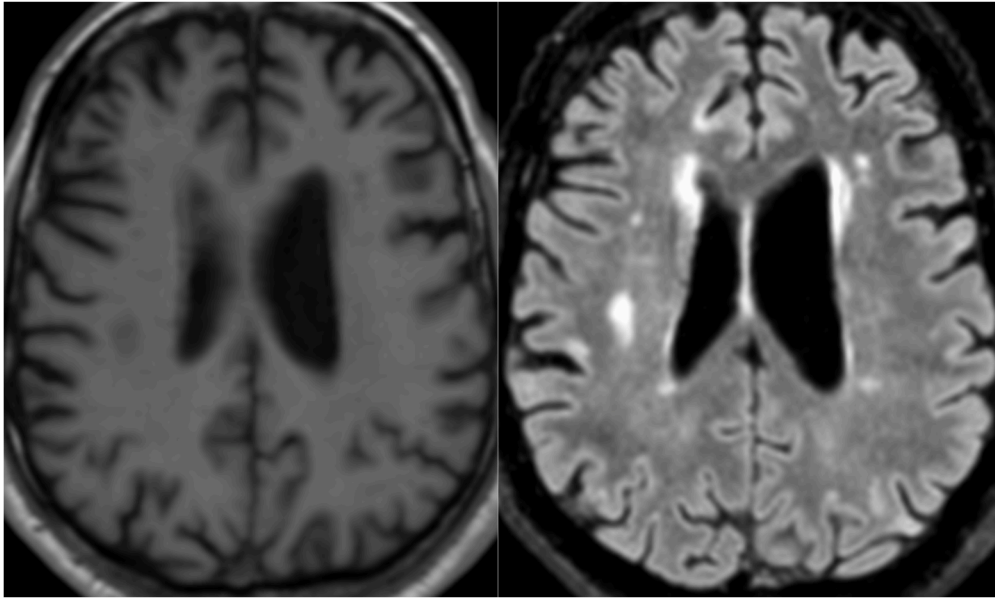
T1 (left) and FLAIR (right) sequences of the same slices. Note that only a part of FLAIR hyperintense lesions are black holes in T1.
